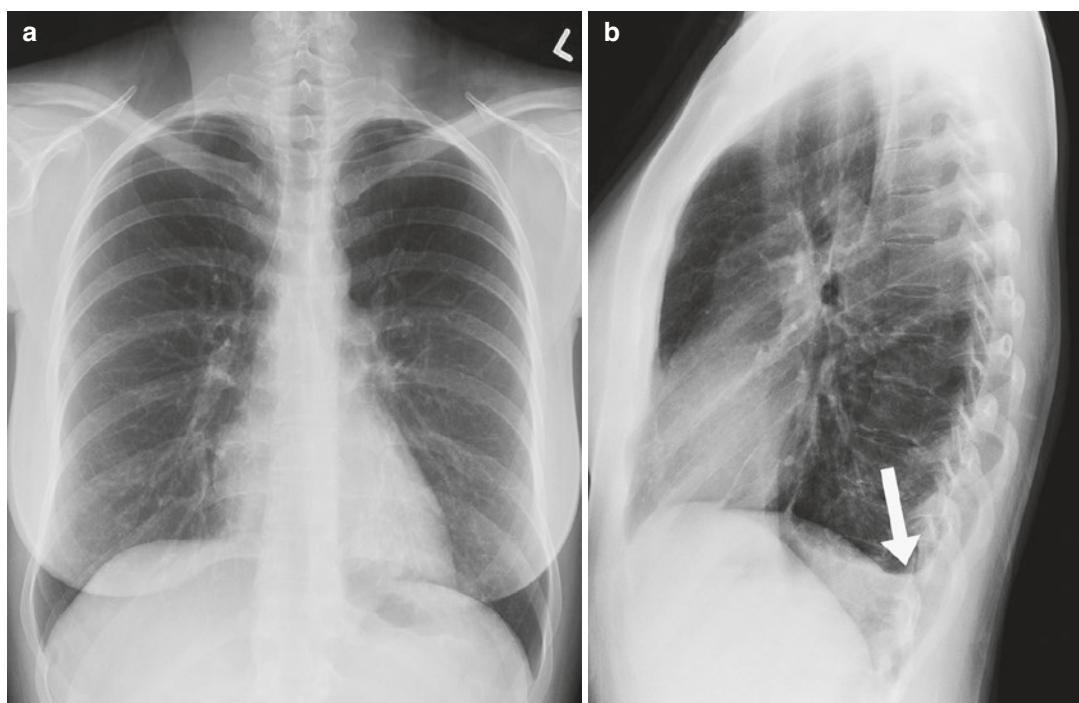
(a, b) PA and lateral radiograph in a 33-year-old woman demonstrates a small left pleural effusion (arrow) visible on the lateral radiograph only
